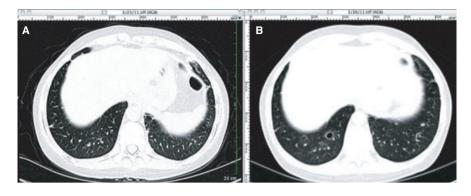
Computed tomography scan of chest with cuts through the right lower lobe demonstrating (A) clear lung fields in the allograft on high-resolution scan and (B) new development of bronchiectasis on routine scan 1 week later.
